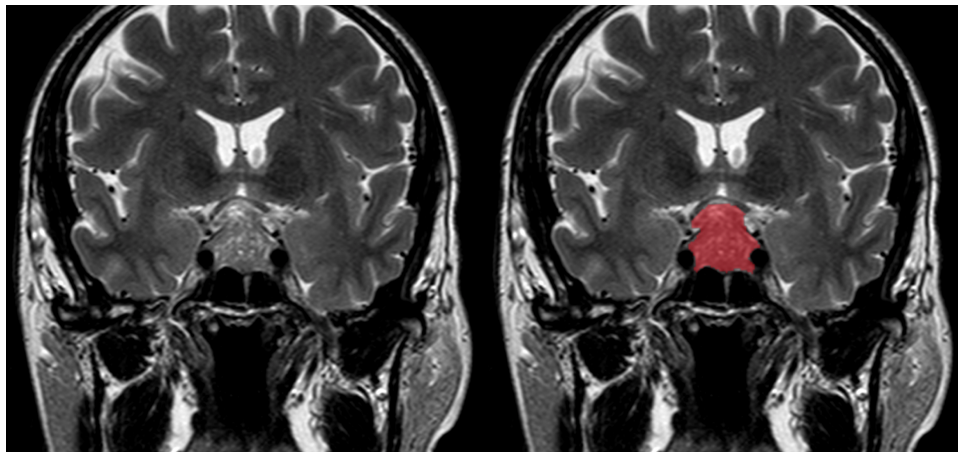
Coronal T2-weighted MRI exam showing the maximum extension slice of a functioning pituitary macroadenoma (A). Image B depicts the result of the image annotation of the region of interest to be employed for subsequent texture feature extraction
